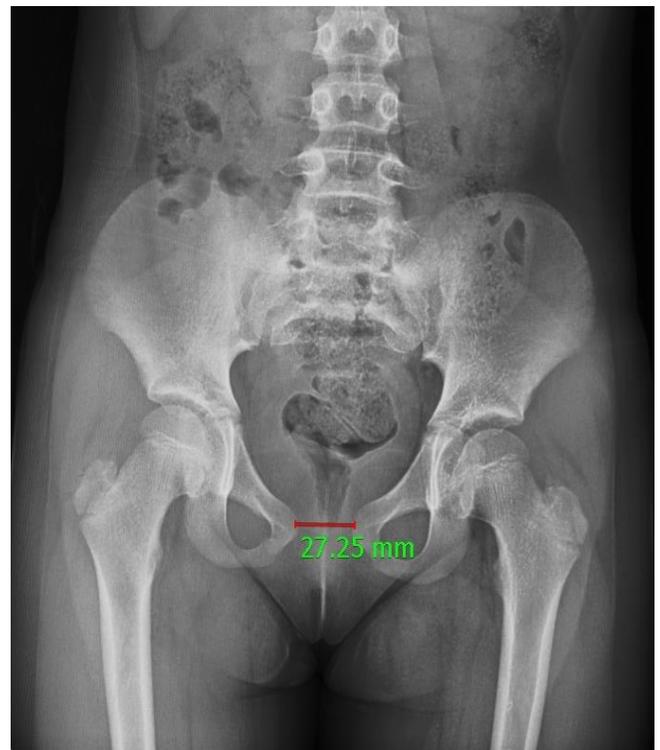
Antero-posterior radiograph of pelvis showing widening of the symphysis pubis (27.25 mm)
